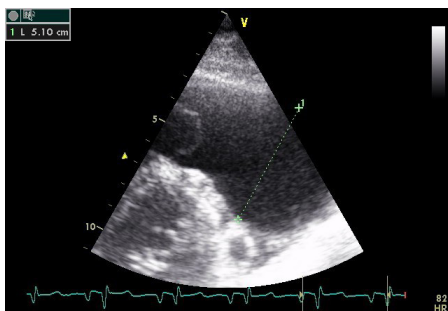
Echo (Modified Parasternal Short-Axis View) Indicating Bowing PV Leaflets and Dilated Main PA.
